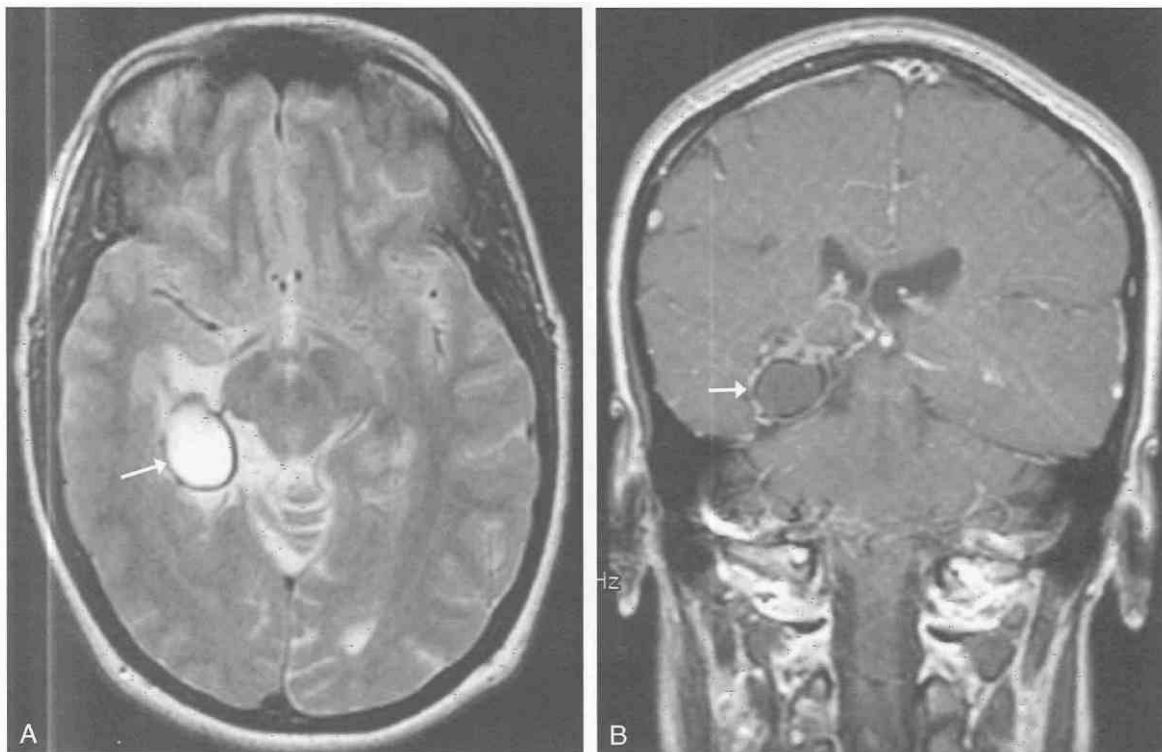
Ganglioglioma of the right temporal lobe. *A*, Axial T2-weighted MR image demonstrates a well circumscribed cystic mass (arrow) with a hypointense rim (secondary to calcification) in the region of the right parahippocampal gyrus and surrounding hyperintensity (due to edema). There is associated mass effect with effacement of the sulci of the right temporooccipital convexity, but there is no evidence of tentorial herniation. *B*, On this postgadolinium T1-weighted coronal image, peripheral rimlike contrast enhancement (arrow) outlines the margins of this cystic tumor, which is located immediately above the right leaf of the tentorium. The contents of the cyst are slightly hyperintense relative to cerebrospinal fluid, reflecting a higher protein content.
